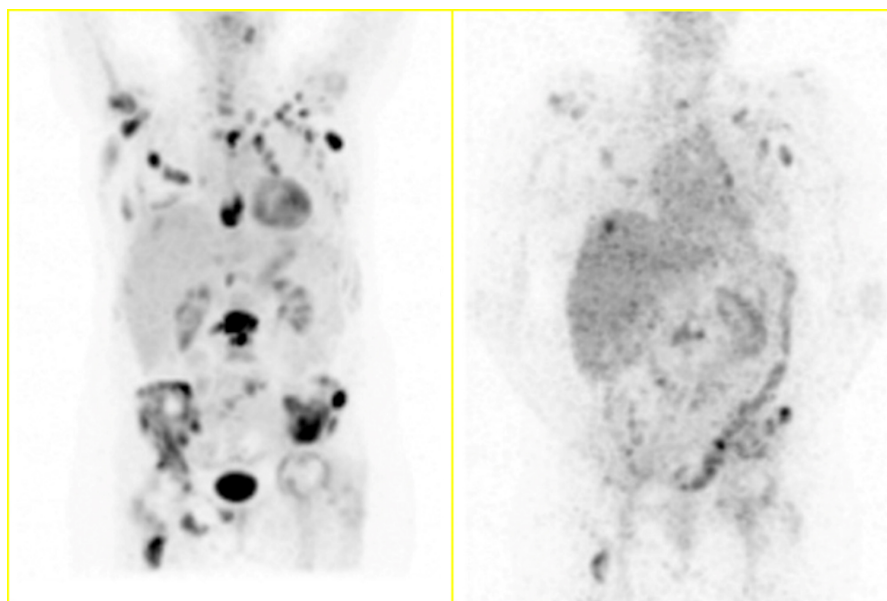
[^{18}F]FDG (left) and [^{89}Zr]trastuzumab PET scans of a woman with metastatic breast cancer. The [^{18}F]FDG scan shows multiple active skeletal and nodal metastases, only a few of which show human epidermal factor receptors 2 (HER2) expression, revealing the heterogeneity of HER2 expression between metastases. Images from the authors' institution (King's College London and Guy's and St. Thomas' PET Centre, St. Thomas' Hospital, London, UK). [^{89}Zr], $^{89}\text{Zirconium}$.
